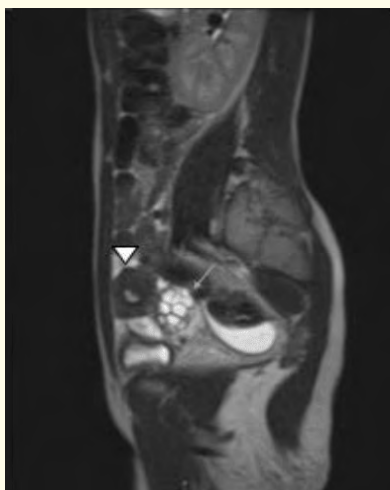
MRI: Sagittal T2WI shows normal right uterine horn (arrowhead) and normal right ovary (arrow).
